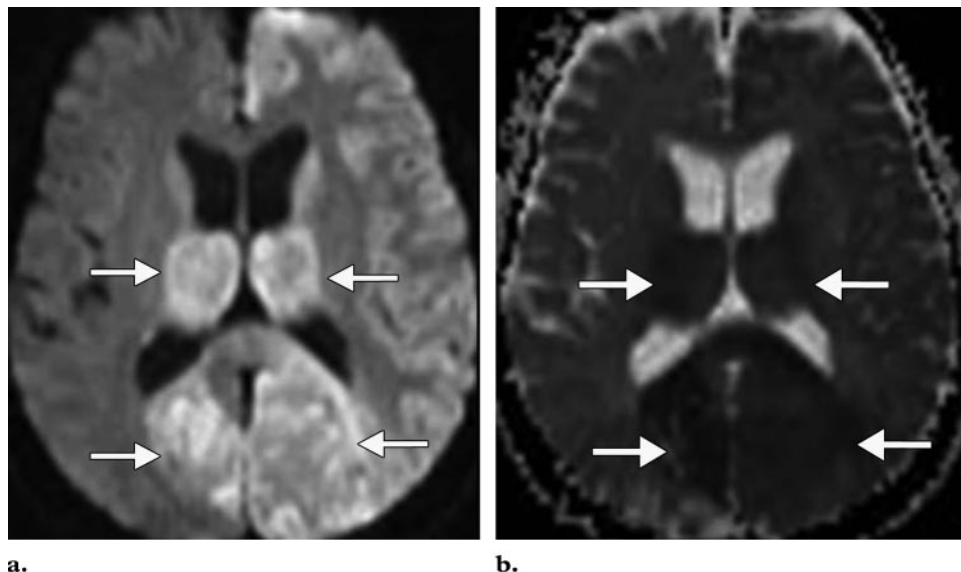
Acute stroke of the posterior circulation in a 77-year-old man. (a) Diffusion-weighted MR image ($b = 1000 \text{ sec/mm}^2$) shows bilateral areas of increased signal intensity (arrows) in the thalami and occipital lobes. (b) ADC map shows decreased ADC values in the same areas (arrows). These findings are indicative of acute ischemia.
